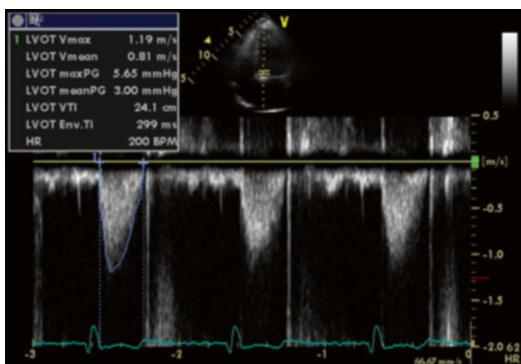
Left Ventricular Outflow Tract (LVOT) Pulsed Wave (PW) Doppler Position 1 (too close to flow convergence adjacent to the prosthetic valve)
